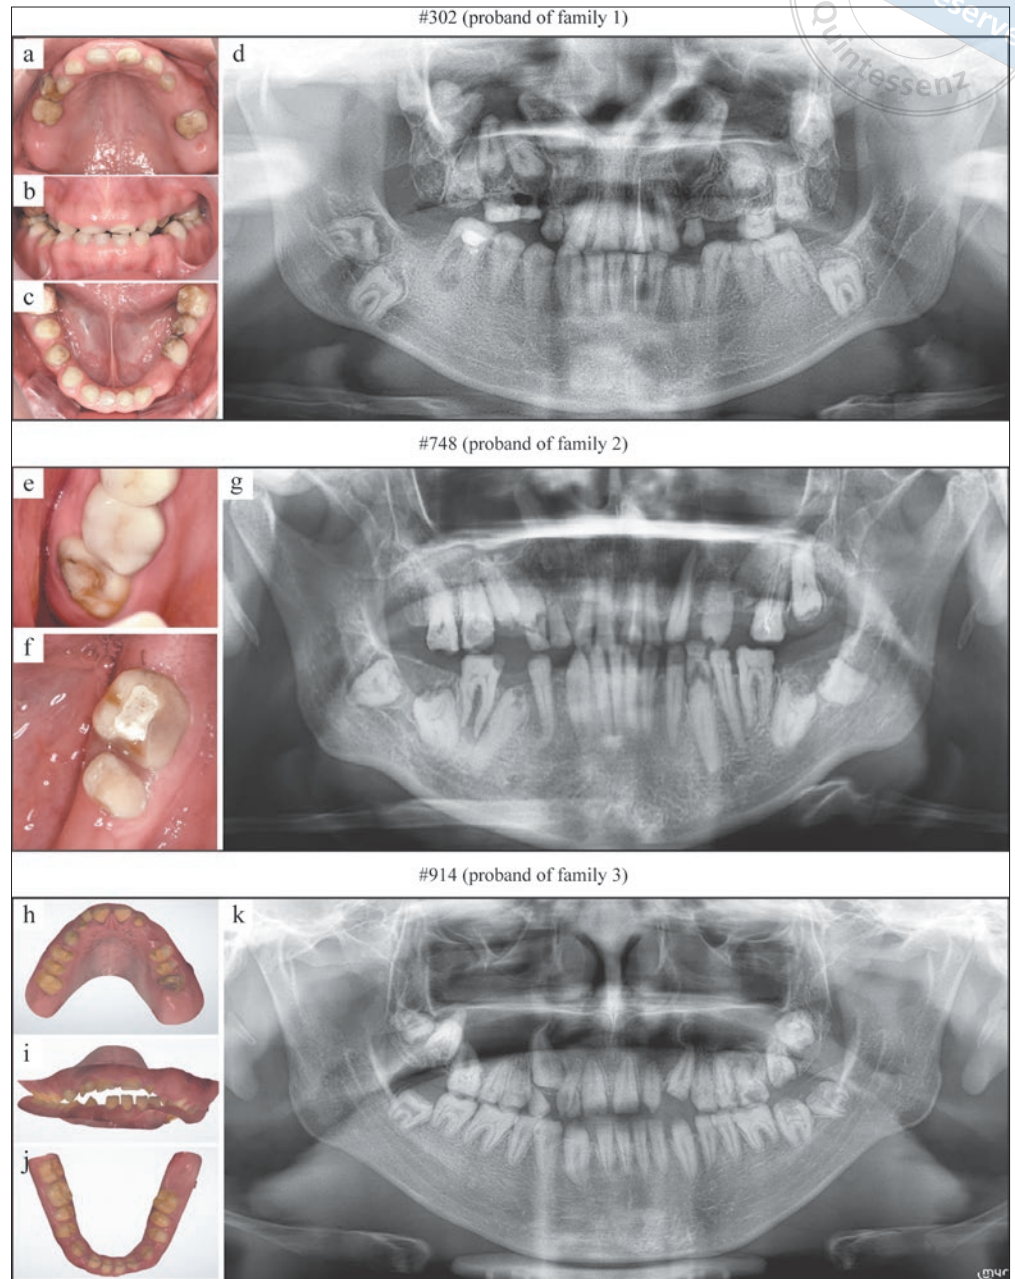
Dental characteristics of the three patients. Digital photographs and panoramic radiograph of proband 302 (a to d) and proband 748 (e to g). Intraoral scan images and panoramic radiograph of proband #914 (h to k).
